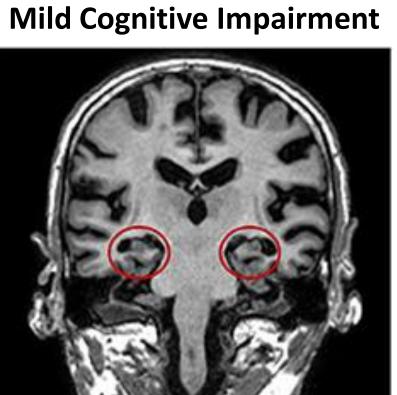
Hippocampal volume magnetic resonance imaging
